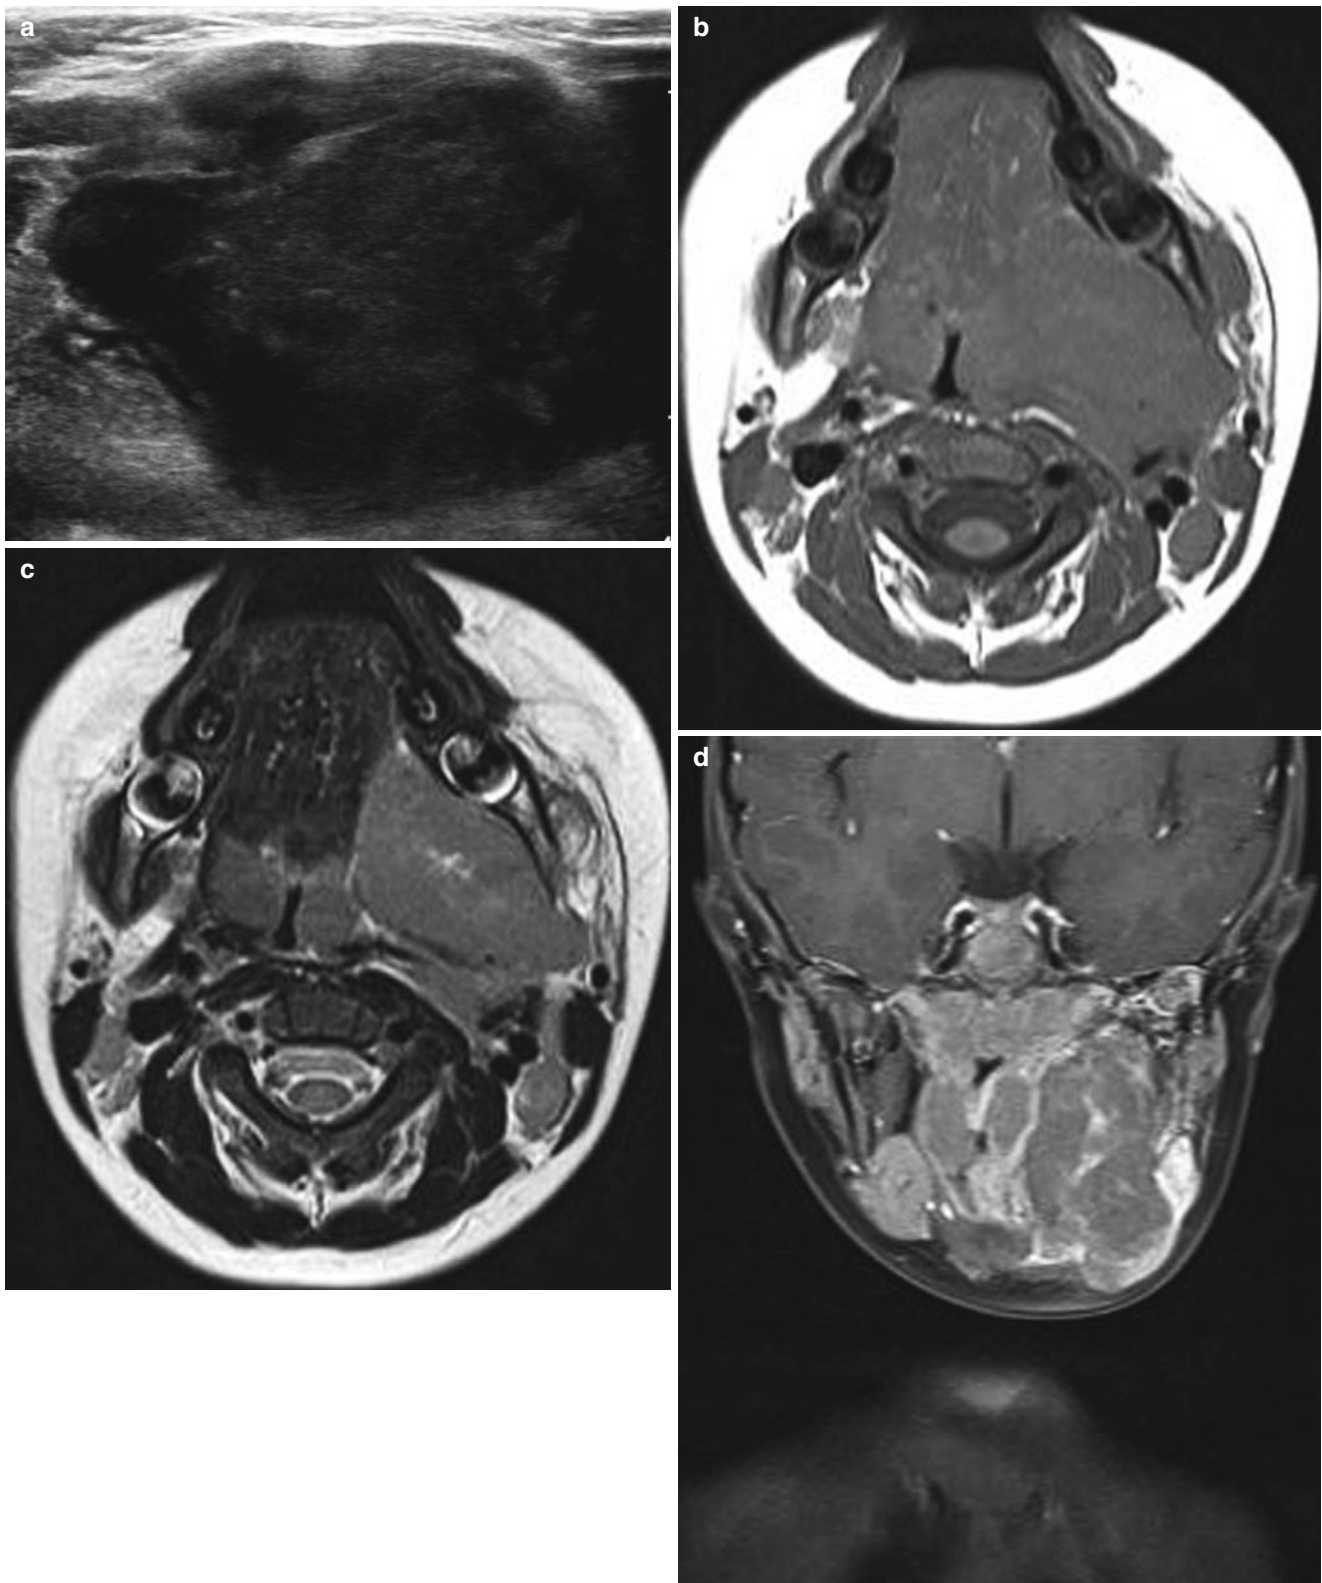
NHL in a 3-year-old boy. (a) US shows large, very hypoechoic (“pseudocystic”) mass in the left submandibular space. (b, c) Axial T1- and T2-weighted MR images show nodular enlargement of both lingual tonsils with homogeneous iso-signal intensity, a bulky soft tissue mass in the left submandibular space, and noncontiguous cervical lymph nodes in the retropharyngeal and posterior cervical
